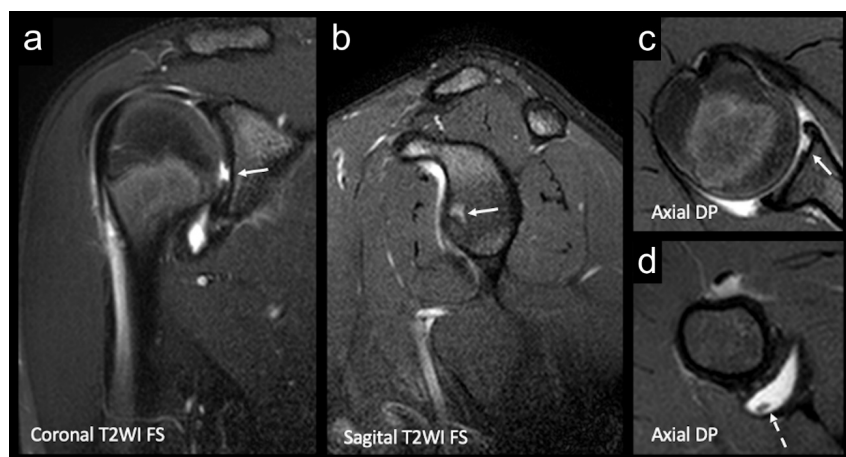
A 21-year-old male who presented with right shoulder pain after strenuous physical activity. (A–C) Fat-saturated T2-weighted MRI sequences showing a deep focal chondral lesion in the anterior region of the glenoid (arrows). (D) A chondral fragment was detected in the axillary recess (dashed arrow).
